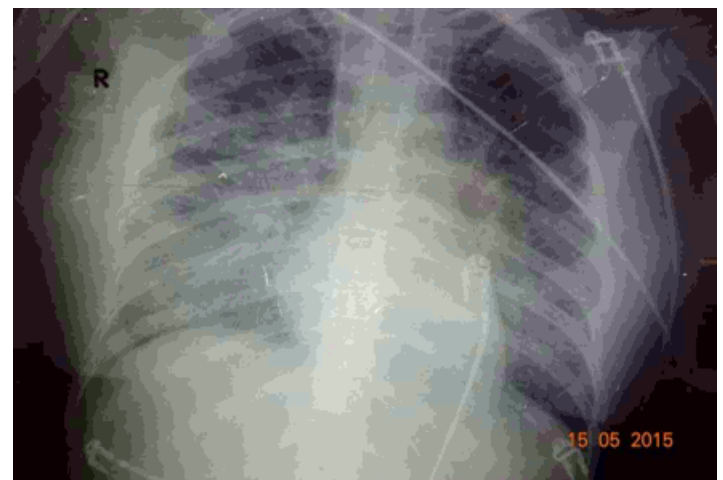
Thorax-X-Ray (1st Day in the ICU)
